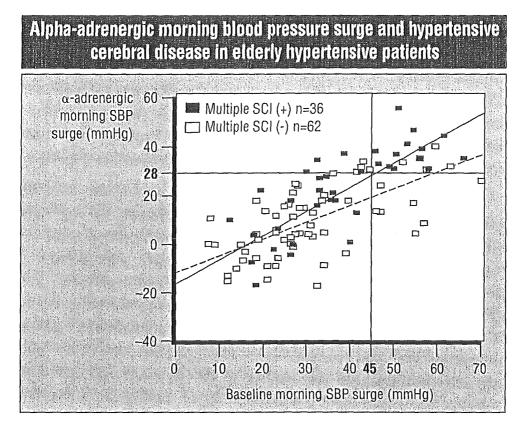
SBP, systolic blood pressure; SCI, silent cerebral infarcts (detected by brain magnetic resonance imaging). Reproduced with permission from Am J Hypertens 2004; 17:668–675.
